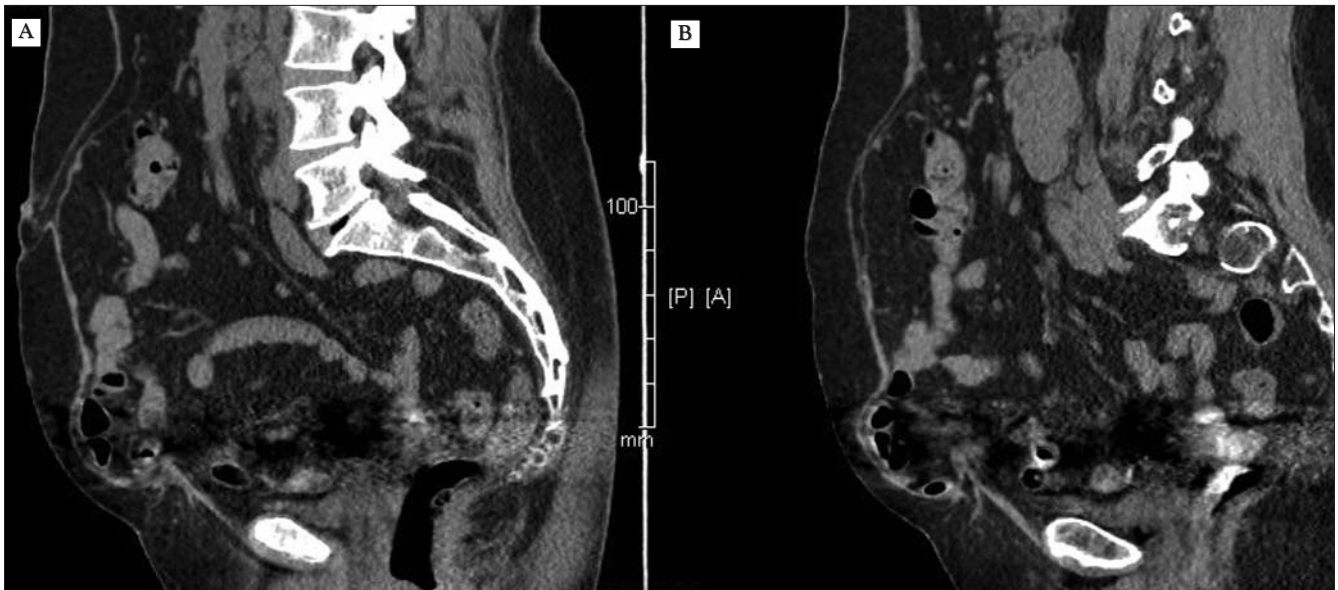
(A) Recurrent supraumbilical incisional hernia after laparoscopic repair: CT scan features; (B) Same patient, during Valsalva
